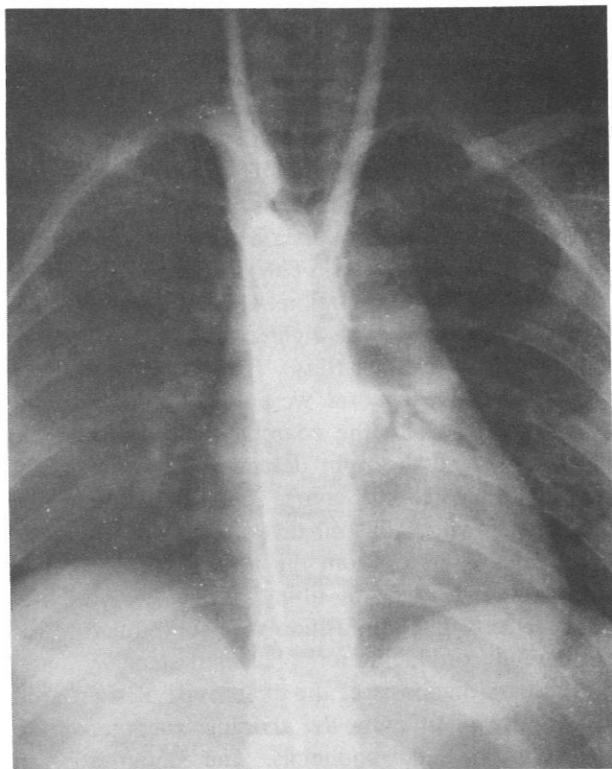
(left). Serial aortic angiogram delineating the left common carotid, right common carotid and dilated right subclavian artery, all of which arise proximal to the coarcted segment. *2B (right).* X-ray of film taken 0.5 seconds later. Lines show origin of left subclavian artery.
